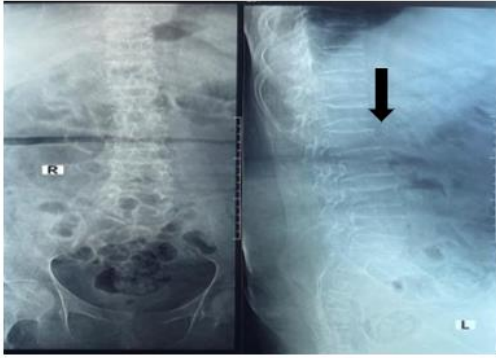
Lumbar X-ray. Lumbar Spondylosis overview.
